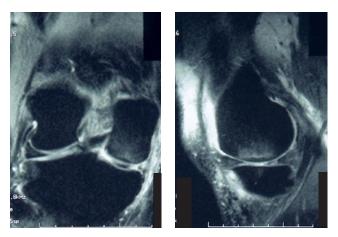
Case 2—12 days before surgery, fat-suppressed T_2 weighted coronal (A) and sagittal (B) magnetic resonance images show posterior horn medial meniscus pathology. There is no definitive evidence of focal spontaneous osteonecrosis of the medial femoral condyle, but there may be, in retrospect, some subtle changes at the articular surface medially. A surgeon who notices these changes should follow the patient and consider bone scanning.
